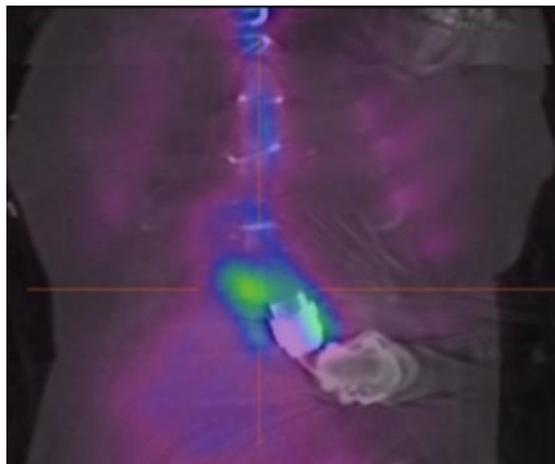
Ga SPECT-CT demonstrating infection limited to the proximal portion of the outflow tract of a HeartMate II LVAD. This allowed for a graft-to-graft anastomosis, and preservation of the distal anastomosis to the aorta.
